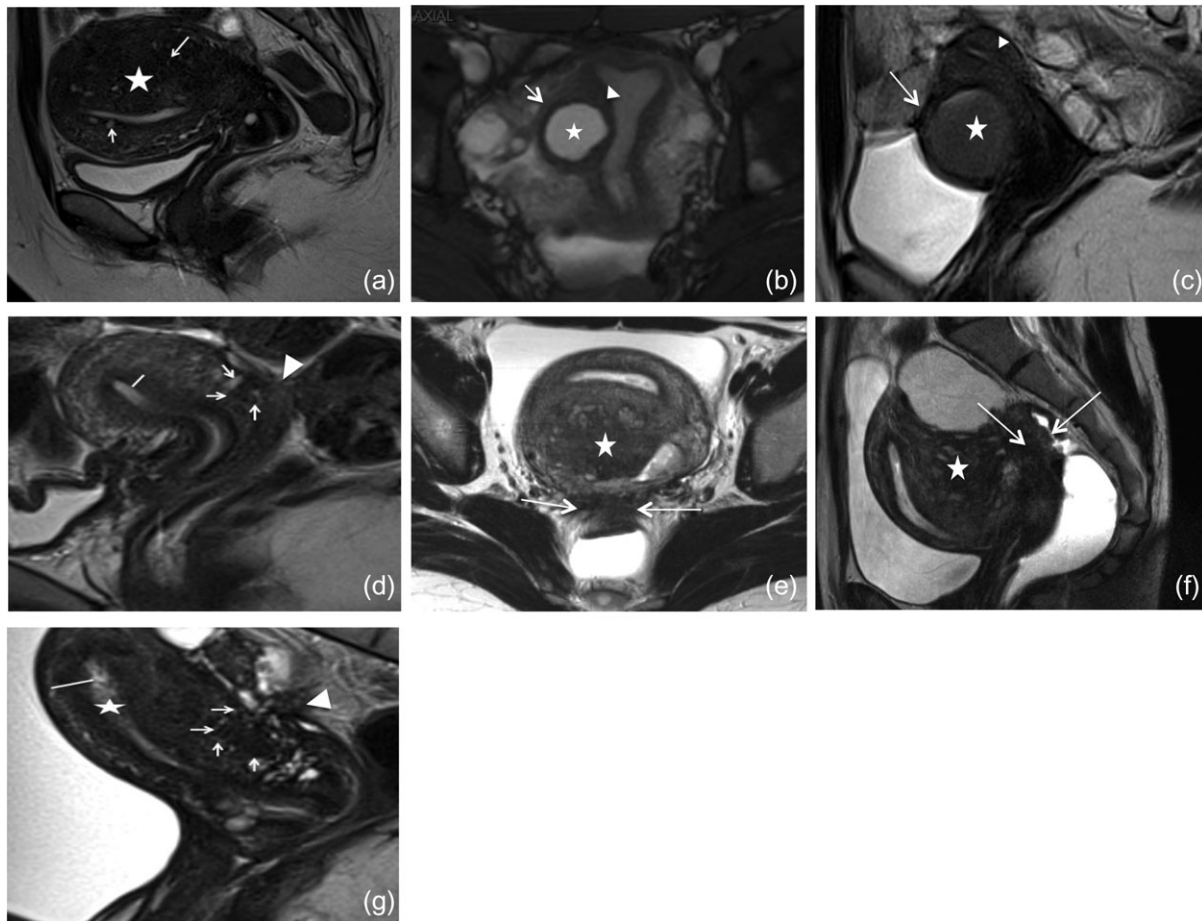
MRI for diffuse and/or focal adenomyosis. (a) MRI with Isolated diffuse adenomyosis (a 34-year-old woman). MRI sagittal T2-weighted section with an overall enlargement of the uterus, with an asymmetric wall of the myometrium, significant thickening of the JZ (white star), with numerous hyper T2 foci (white arrows), predominantly in the posterior myometrium, suggesting asymmetric diffuse adenomyosis; (b and c) MRI with isolated focal adenomyoma (sub-type III Kishi). MRI coronal T2-weighted (b) and sagittal T2-weighted (c) image of intramural adenomyosis. The focal adenomyoma (white star) is located in the right lateral edge of the uterus. Intact myometrium surrounds the lesion. The JZ (white arrowhead) and the serosa (white arrow) are preserved. (d) MRI with isolated FAOM (sub-type II Kishi) (Kishi et al., 2012) (a 31-year-old woman). MRI sagittal T2-weighted image reveals a focal hypointense focused area in the posterior wall of the myometrium (white arrows) exhibiting focal adenomyosis located in the outer myometrium without any diffuse adenomyosis (thin Junctional Zona (white line), and no hyperintense T2 foci). The intermediate intensity reaching at least up to the fundal part of the uterine cavity, corresponds to a partial volume on the endometrium. The lesion is contiguous to a deep infiltrating lesion (white arrowhead). (e and f) MRI with isolated posterior FAOM (sub-type II Kishi) (Kishi et al., 2012) (a 34-year-old woman). MRI Axial T2-weighted (e) and sagittal T2-weighted (f) image demonstrates focal hypointense focused area, located in the posterior wall of the myometrium (white star). The lesion is contiguous to a deep infiltrating bowel lesion (white arrow). (g) MRI with associated diffuse and FAOM (sub-type II Kishi) (Kishi et al., 2012) (a 32-year-old woman). MRI sagittal T2-weighted image through the mid portion of the uterus reveals focalized posterior adenomyosis (FAOM) (white arrows) with hyperintense focal signals. Diffuse adenomyosis added as a thickening of the JZ (black area highlighted by the white line) anterior and posterior to the hyperintense normal appearing endometrium (white star). FOAM is contiguous to a deep infiltrating lesion (white arrowhead). JZ, junctional zone; MRI, magnetic resonance imaging; FAOM, focal adenomyosis located in the outer myometrium.
